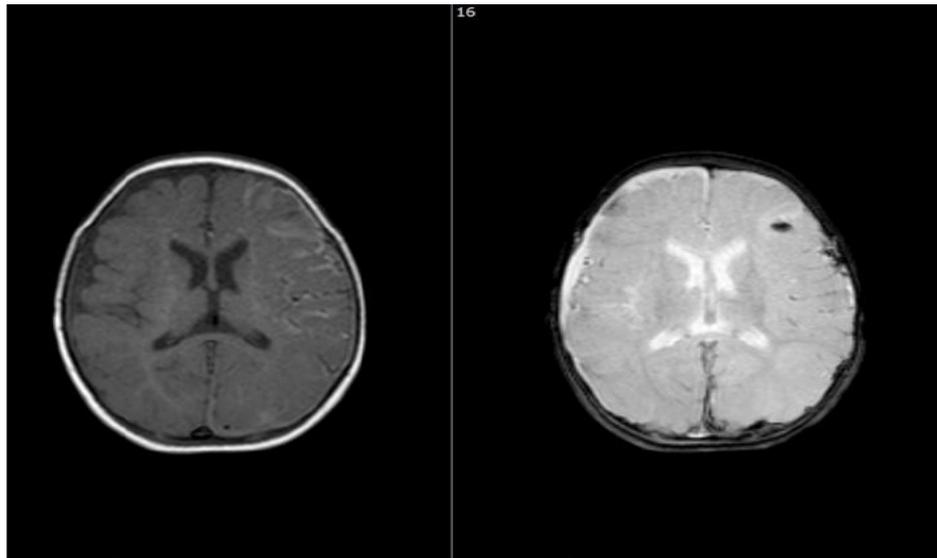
MRI images, left T1 weighted, right T2 weighted.
